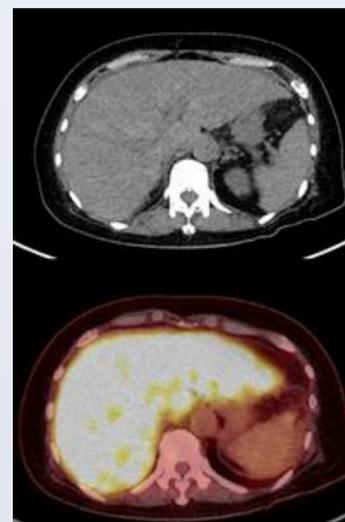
F-18 FDG PET CT images demonstrate intense hypermetabolism involving the entire liver which is diffusely nodular with small volume ascites in a patient with known metastatic breast cancer and pseudocirrhosis.
